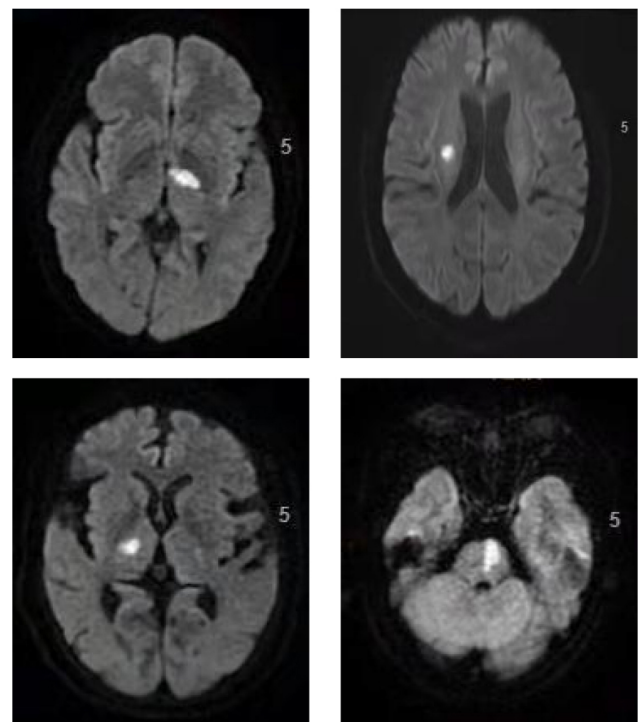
Imaging of patients with ischemic stroke. Magnetic resonance imaging showed the left lateral thalamic lacunar infarction, right lateral paraventricular lacunar infarction, right basal segment infarction and left cerebral bridge infarction.
